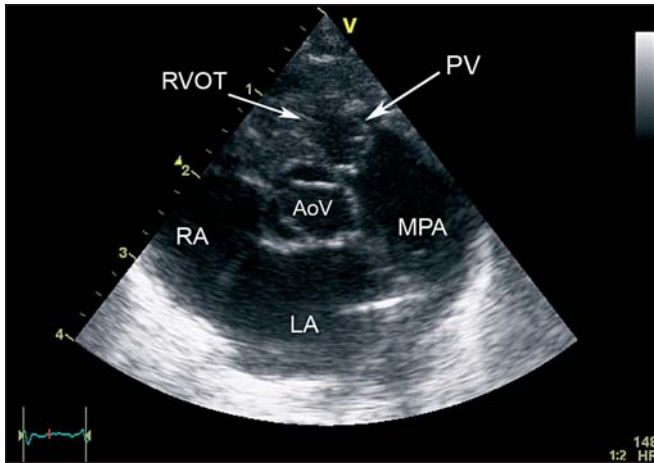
Parasternal short-axis view showing a hypertrophied right ventricular outflow tract, doming of the pulmonary valve (PV), poststenotic dilatation of the main pulmonary artery (MPA), an open aortic valve (AoV), and the left and right atrium (LA, RA).
